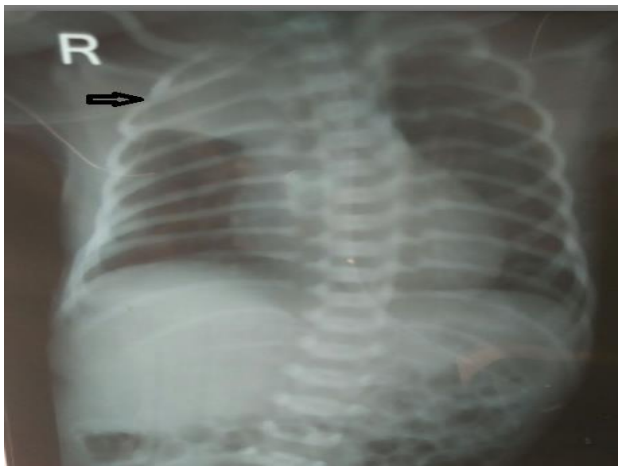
X-ray chest showing right upper lobe collapse.
